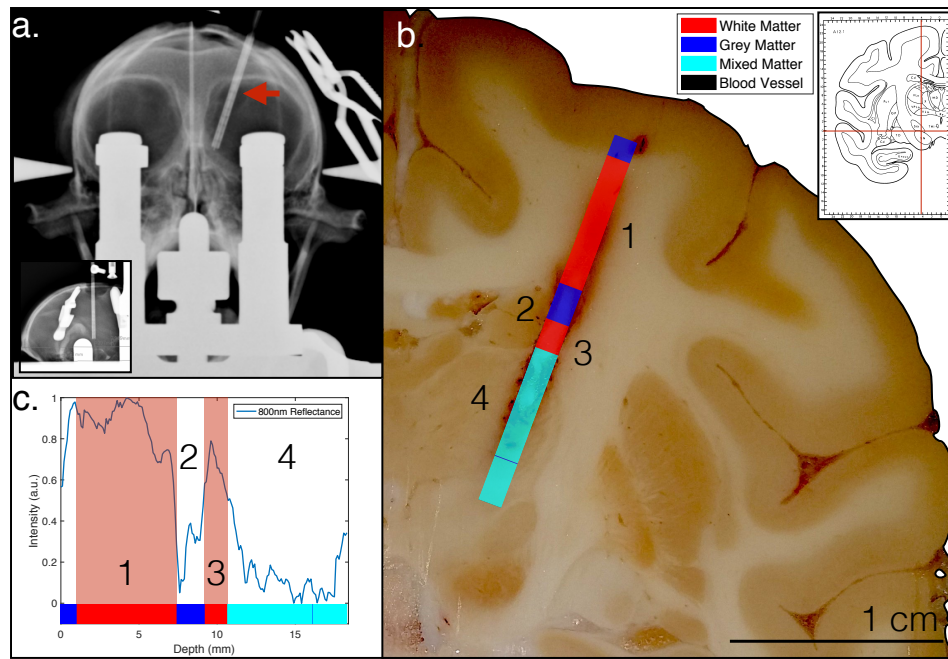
In Vivo* Stereotactic single angle, DBS lead implantation in NHP with fibre optic stylet, off target. a.) X-ray image showing the lead implant location in the left hemisphere of the NHP brain. b.) Shows Post-mortem brain slice of brain where implantation occurred. Inset in top right shows the calculated position designated by the cross-hairs on an atlas image according to the X-ray measurements made during the implantation. Discrimination plot is superimposed over the area where the probe was sent down during the surgery with the region numbers referring to the following: 1 - white matter, 2 - caudate nucleus, 3 - white matter, 4 – thalamus c.) NIR Intensity plot over trajectory starting at cortex/white matter boundary. Region numbers are located in the position along the trajectory that correspond to their respective brain regions according to the brain slice. Red sections signify algorithm-detected white matter
